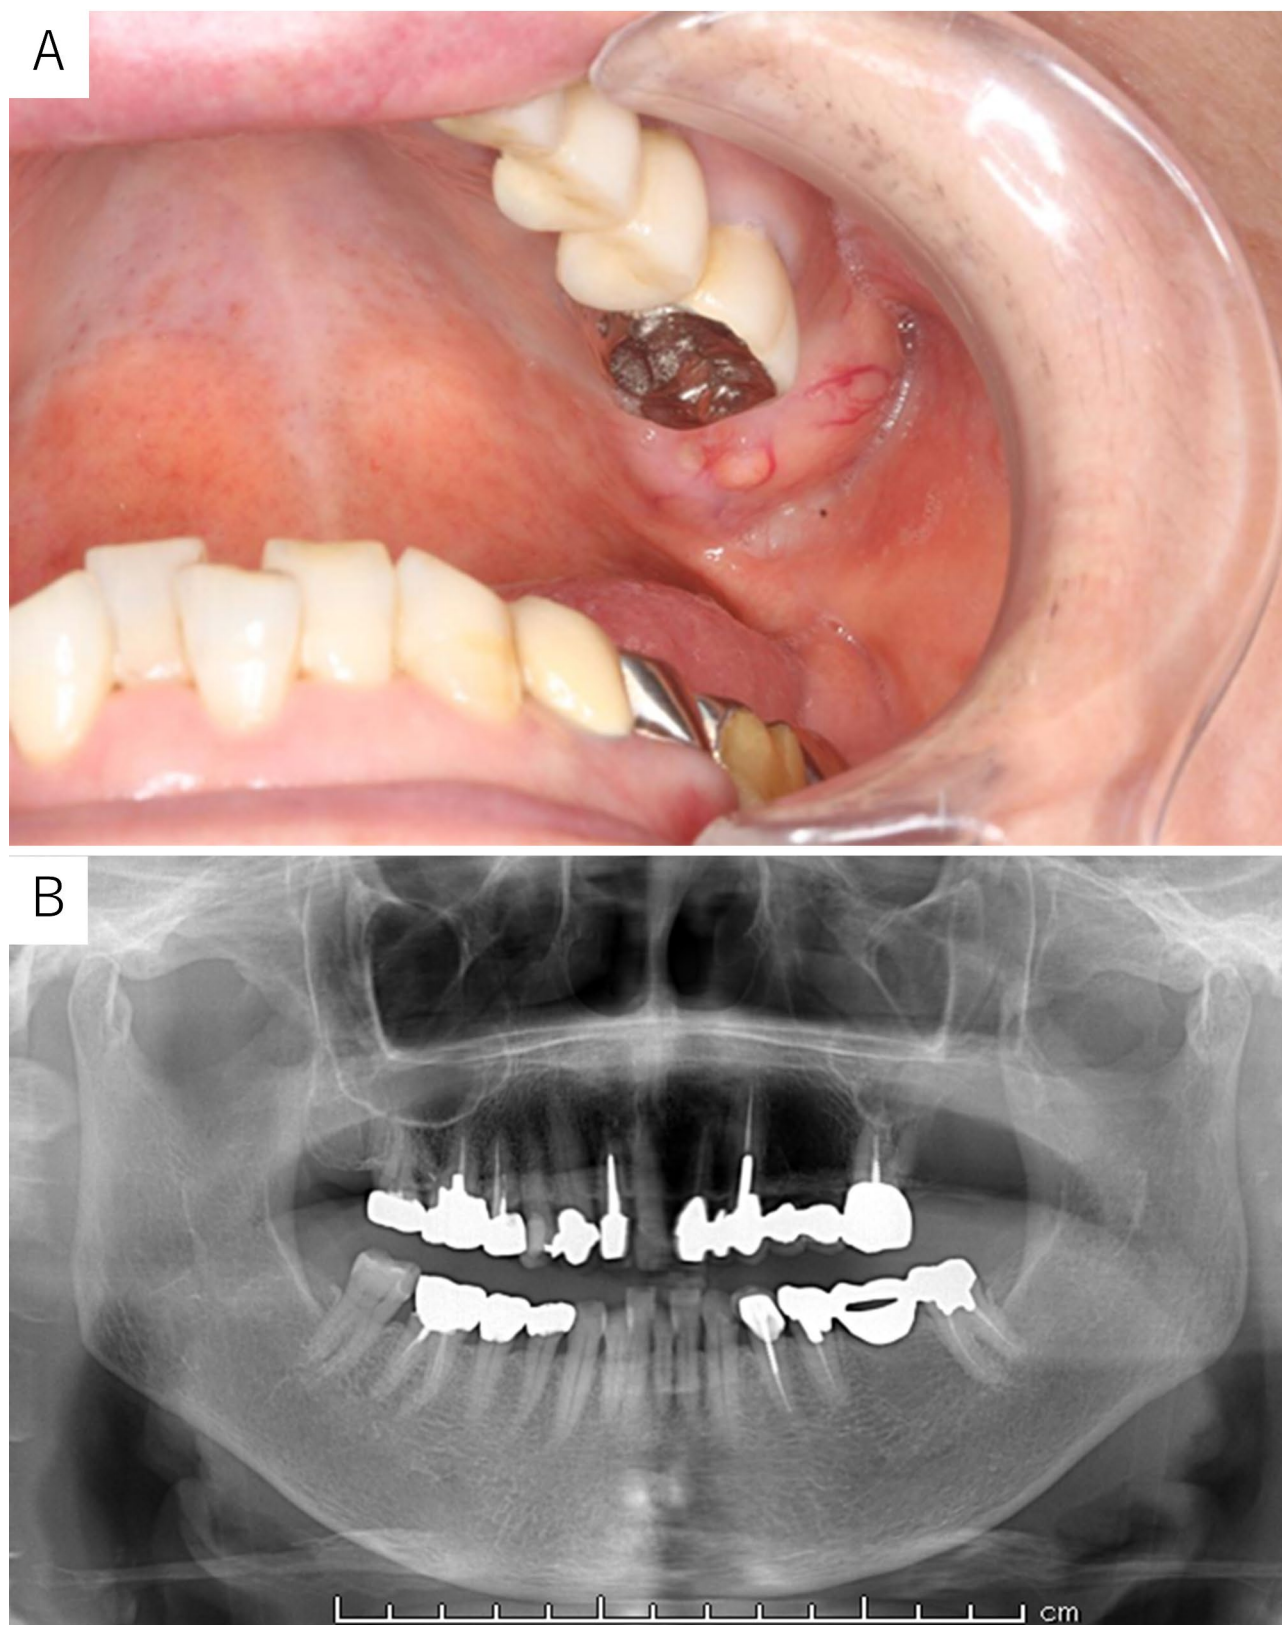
(A) Intraoral photograph, taken at first visit, of a mass on the left upper jaw, covered with normal mucosa. (B) Panoramic radiograph showing well-defined bone loss from the mesial side of the first molar in the left maxilla; the border between the lesion and the maxillary sinus was unclear
